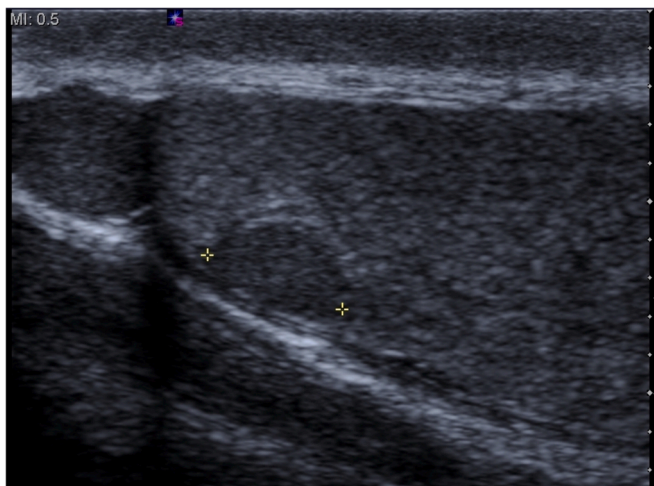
Longitudinal ultrasound image of the left testicle demonstrating a solid, hypoechoic mass within the upper pole.
